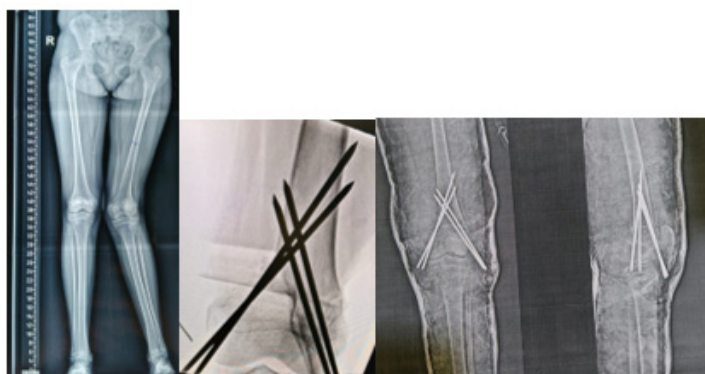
Serial radiographs demonstrating tibial deformity correction and stabilization with Kirschner wire fixation.
